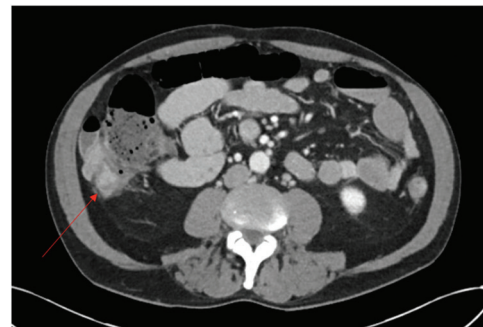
Axial view, CT abdomen and pelvis with contrast on November 9th, 2021. Red arrow demonstrates flegmon and dilated cecum anteriorly.
